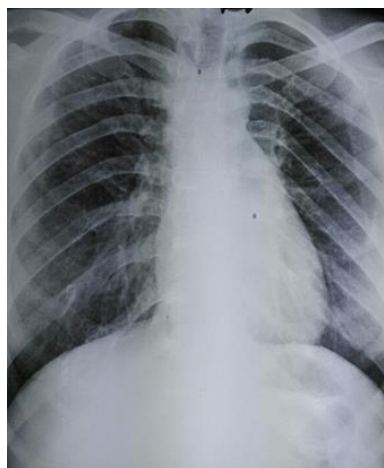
Chest radiograph showing bifid ribs.
